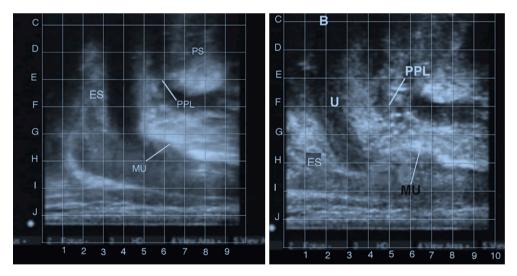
Transperineal ultrasound of a male with SUI. Transperineal ultrasound of a male with SUI. Three reflex muscle forces, backward, downward, and forward stretch the proximal male urethra backwards/downwards and the distal (MU) forwards & upwards, as in the female. Left figure (at rest). The lower level of proximal urethra ES is at G4. MU runs between G4 and H7. PPL is at E6. Right figure (during straining). Three reflex muscle forces, backward, downward, and forward stretch the proximal male urethra backwards/downwards and the distal (MU) forwards and upwards. ES has been pulled backwards and downwards. The lower level of ES is just below H 2.5. PPL has stretched considerably backward, from E6 to G5, almost double, indicating weakness; MU has moved very considerably upwards relative to the lower end of ES, indicating a forward force applied from behind, as seen in the distal urethra in the female. Reused from (1). Copyright 2022, with permission from Karger. ES, external sphincter; PS, pubic symphysis; PPL, puboprostatic ligament; MU, membranous urethra; B, bladder; U, urethra; SUI, stress urinary incontinence.
